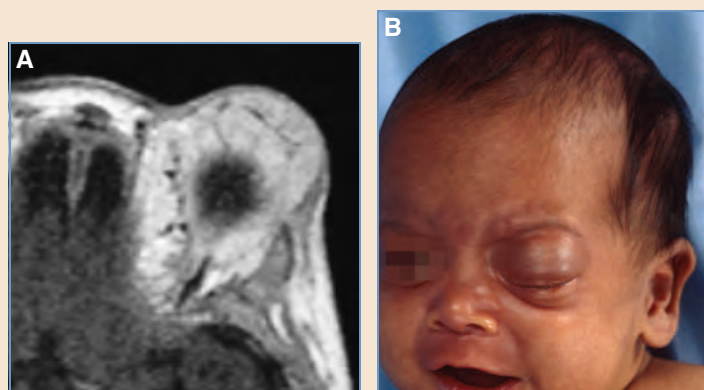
Orbital proliferative infantile hemangioma. A, MRI shows typical flow voids in a proliferative tumor in a baby. Flow voids are seen as small channels of signal loss. B, Orbital hemangioma.
